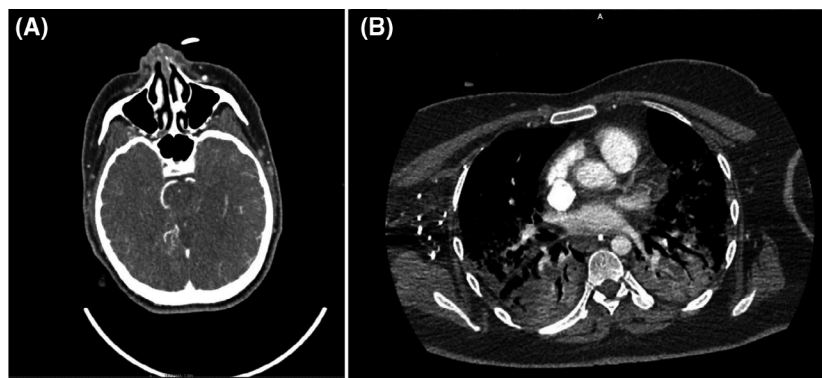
(A) Non-contrasted CT scan of the head with intracranial angiogram showing established acute infarcts in the PCA territories bilaterally extending to the left hippocampus and left and midbrain; hyperdense clots in the basilar artery and P1 segment of the left PCA on the non-contrasted CT brain which are confirmed with cessation of contrast in the angiogram. (B) CT scan of the chest with pulmonary angiogram showing right lower lobar pulmonary embolism; extensive bilateral ground-glass and patchy solid consolidation in keeping with established Covid-19 infection.
